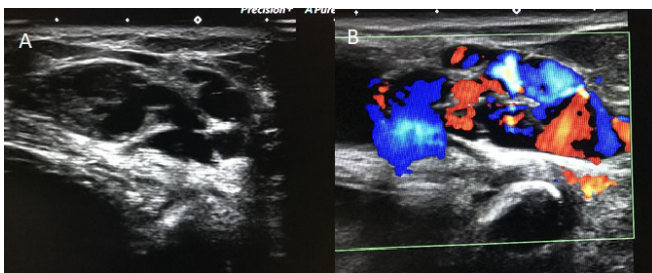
A 34-year-old woman at the 24th week of pregnancy with round ligament varicosities. Gray-scale (A) and color Doppler (B) show a mass in the left inguinal region composed of multiple serpentine tubular cystic structures filled with color on Doppler imaging (Case 2).
